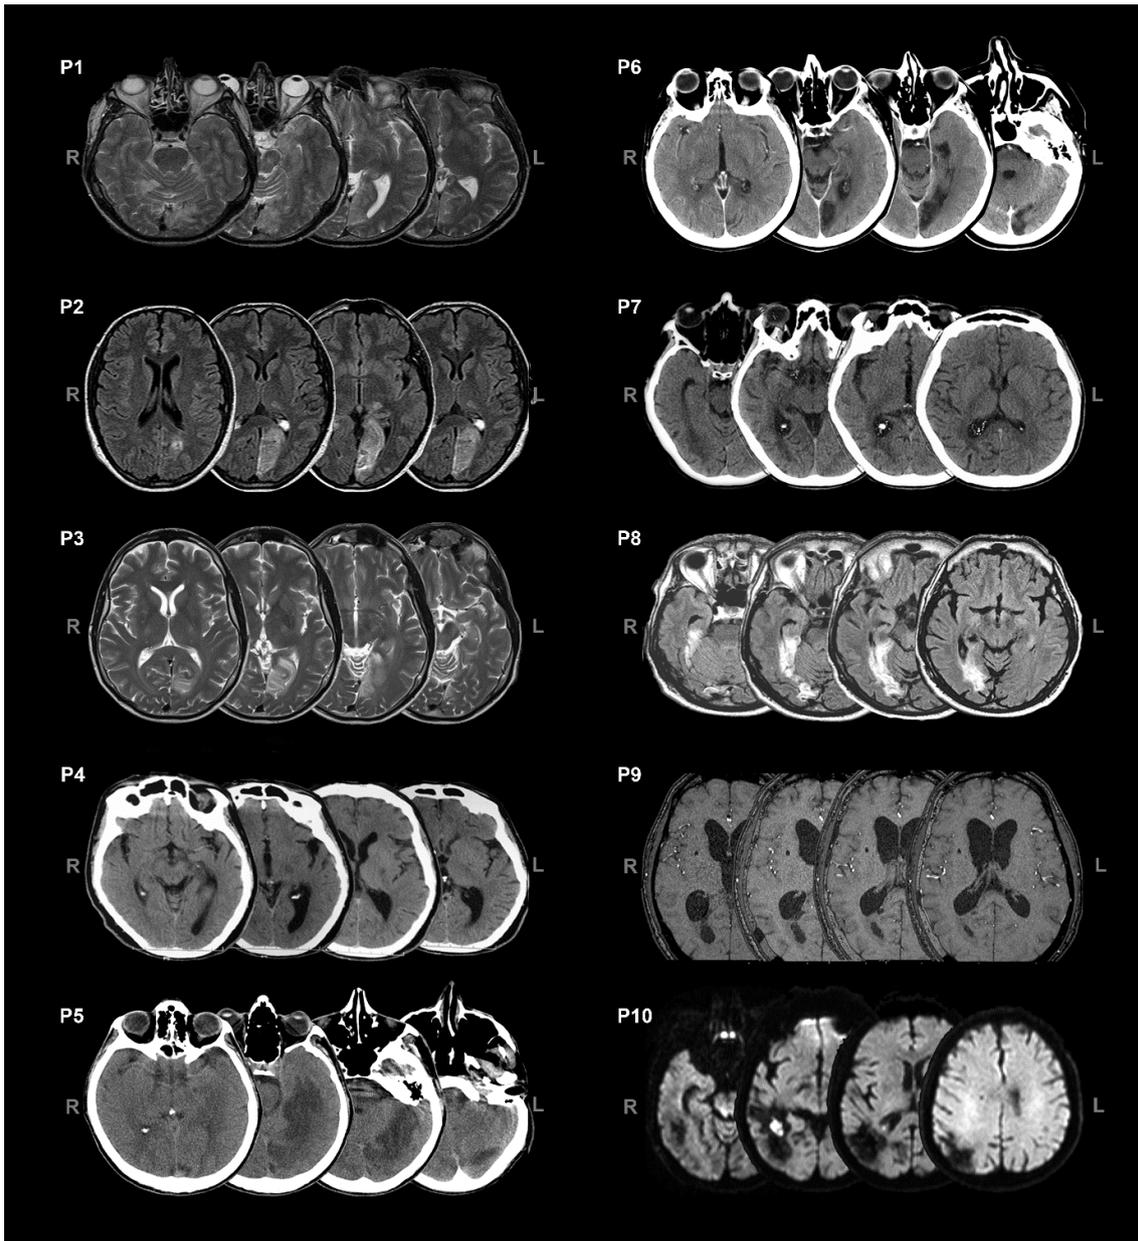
Axial views of CT/MRI scans of the patients. L = left, R = right.
